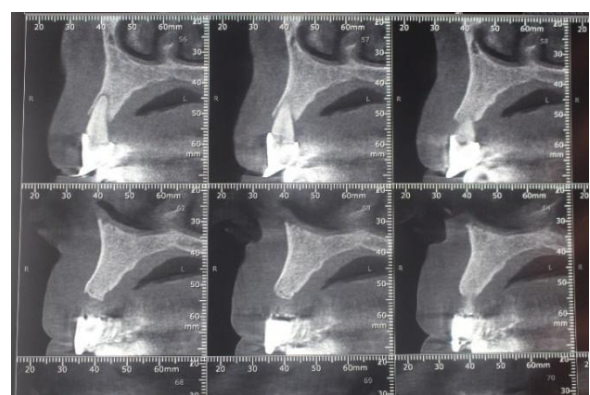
CBCT parasagittal axial views in the premolar region
